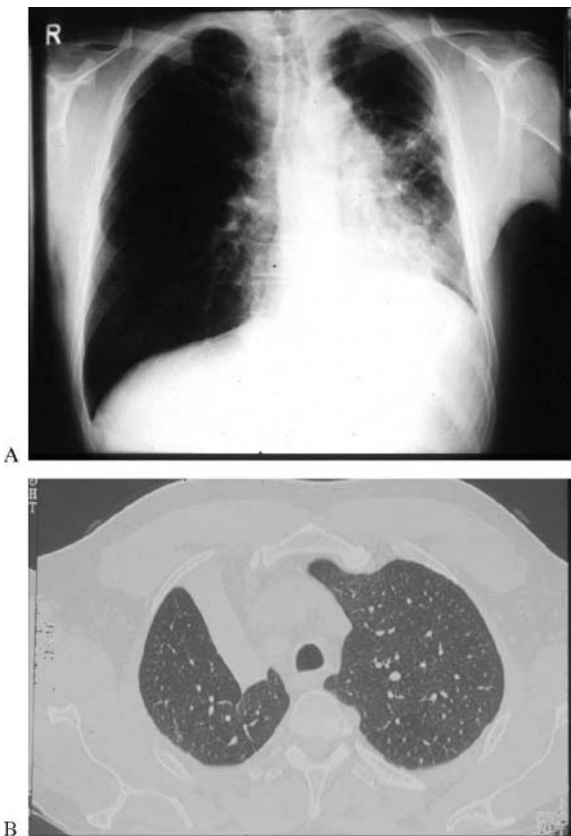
Stenosing and obliterative airway disease in Wegener's granulomatosis. The radiograph on the left (A) shows loss of volume of the right lung due to stenosis of the to main stem bronchus; the apical CT section on the right shows segmental atelectasis.
